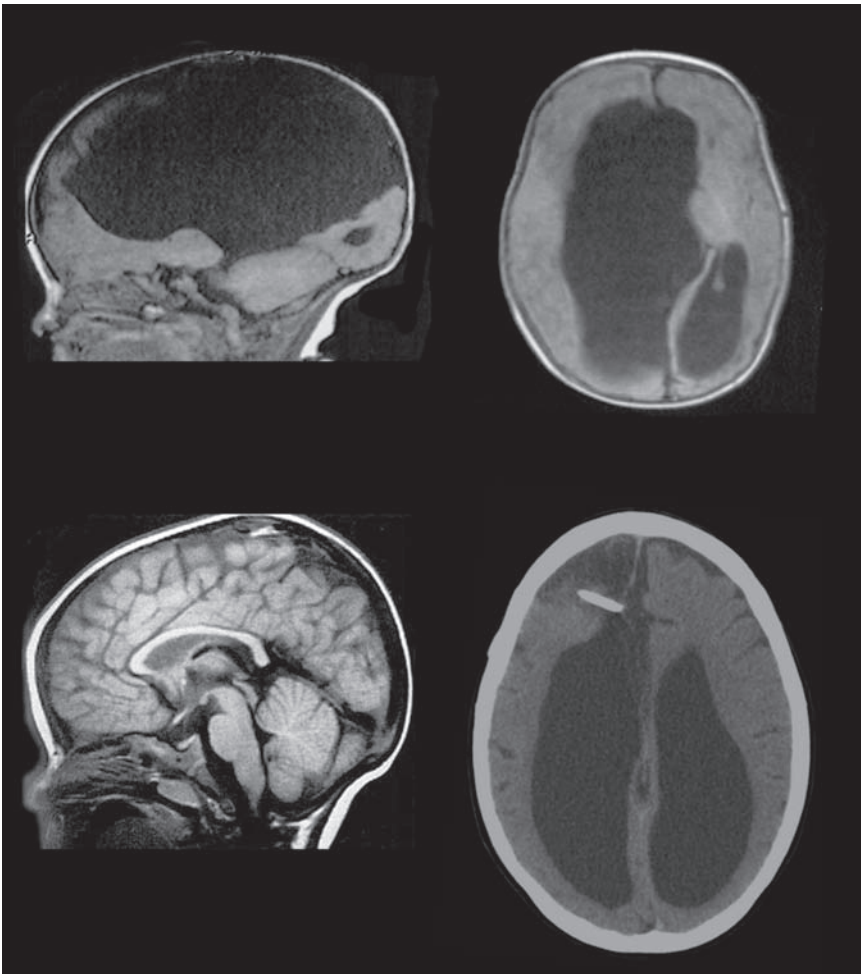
The CT images on the top are of a 2-month-old with an arachnoid cyst in the right frontal region and shunted hydrocephalus. Note the extent of the excess cerebrospinal fluid when compared to an MRI scan of a normal 6-month-old on the bottom left (from Barkovich, 2000; copyright 2000 by Lippincott Williams & Wilkins; reprinted by permission). The bottom right CT scan is from the same patient as in the top row, taken during a routine checkup of shunt functioning when he was 12 years old. Moderate dilation of the lateral ventricles is still apparent.
